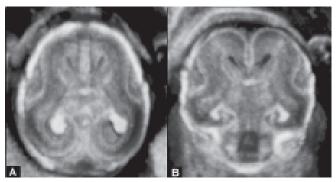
Tomographic ultrasound imaging (TUI) of the fetal brain. Normal brain in the coronal cutting section at 31 weeks of gestation. Intracranial structure including gyral formation is clearly demonstrated
